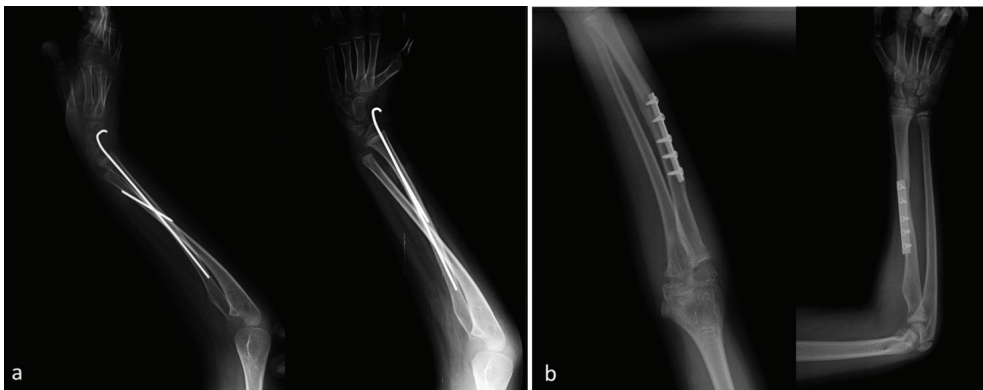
The postoperative radiograph of two patients are shown. (a) Kirschner wire (b) Semi-tubular plate
